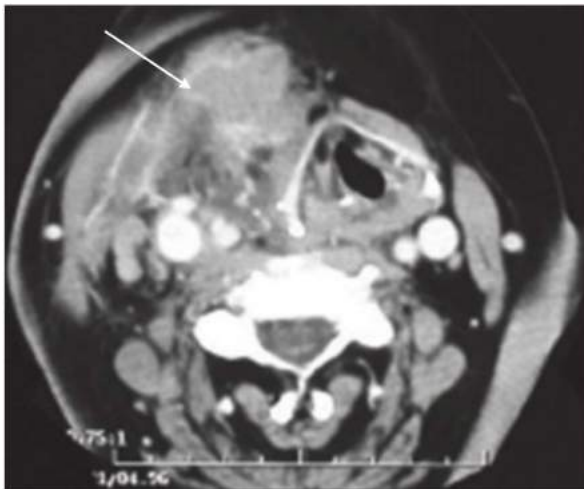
• CT scan of recurrent nodal disease in the lateral neck impinging upon the central compartment (*arrow*). CT is useful in this instance as ultrasound cannot completely define the anatomy.
